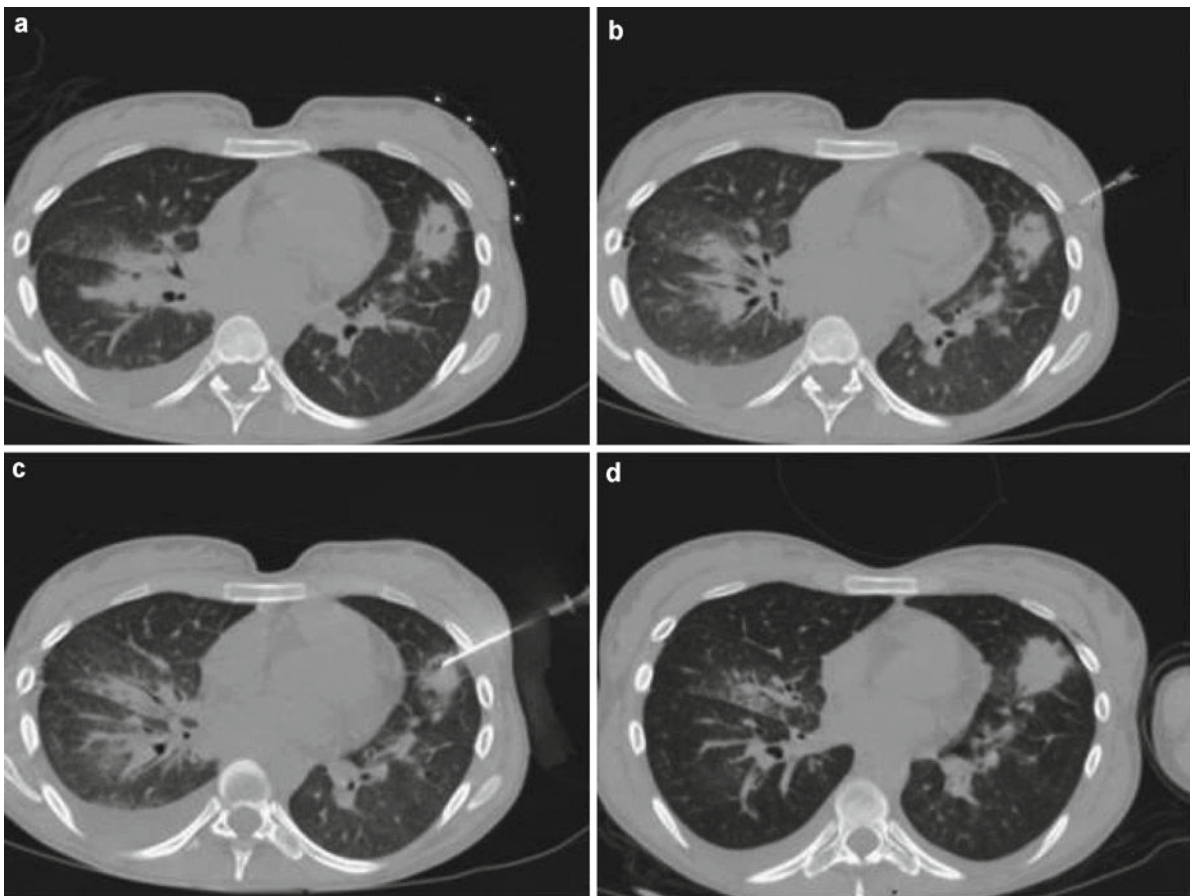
CT-guided lung biopsy in a 64-year-old patient with a long history of chronic lymphoid leukemia and a new lung mass, suggesting aggressive lymphomatous transformation. The biopsy showed tuberculosis
